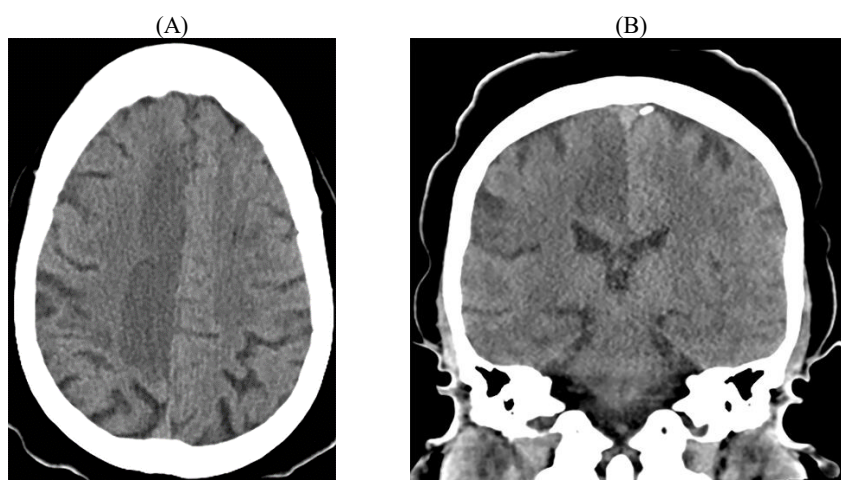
M/35. (A) Transaxial view, (B) Coronal view. This patient was diagnosed with rheumatic heart disease with atrial fibrillation. There was a syncope attack with left hemiplegia. Non-contrast CT reveals an ischemic infarct of the medial side of the right frontoparietal lobe, as the anterior cerebral artery (ACA) territory ischemia.
